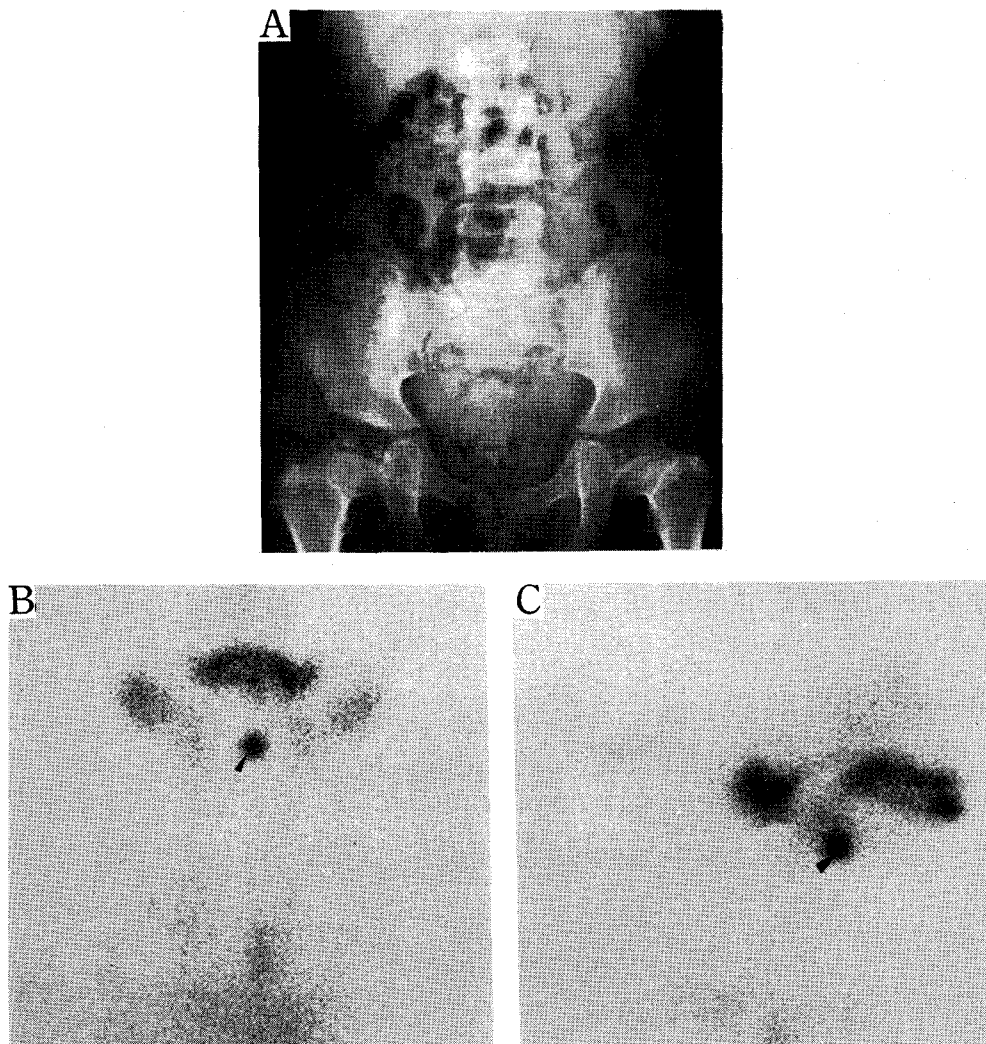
Case 1. Radiograph (a) demonstrates coarse fragmentations in capital femoral epiphyses and flattened lumbar vertebrae with irregular margin. Anterior (b) and lateral (c) views of scintigraph using  $^{99m}\text{Tc}$  pertechnetate reveal no activity over the neck and a focal intense activity at midline of the mandible and inferior to the oropharynx (arrowheads), indicating sublingual thyroid.
